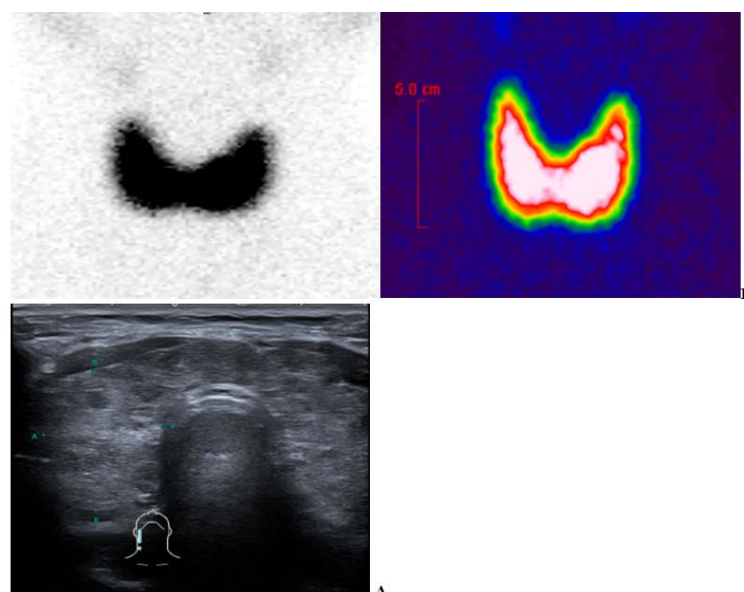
The patient is a 23-year-old woman. Clinic of thyrotoxicosis, laboratory picture of thyrotoxicosis, differential diagnosis between graves and Hashimoto's thyroiditis. a) An ultrasound study shows diffuse inhomogeneous thyroid parenchyma with small, reduced echogenicity inclusions. b) Increased Tc99 uptake was detected in radioisotope investigation 5.5% (norms 1,0%-2,0%). Diagnosis: diffuse toxic goiter.
